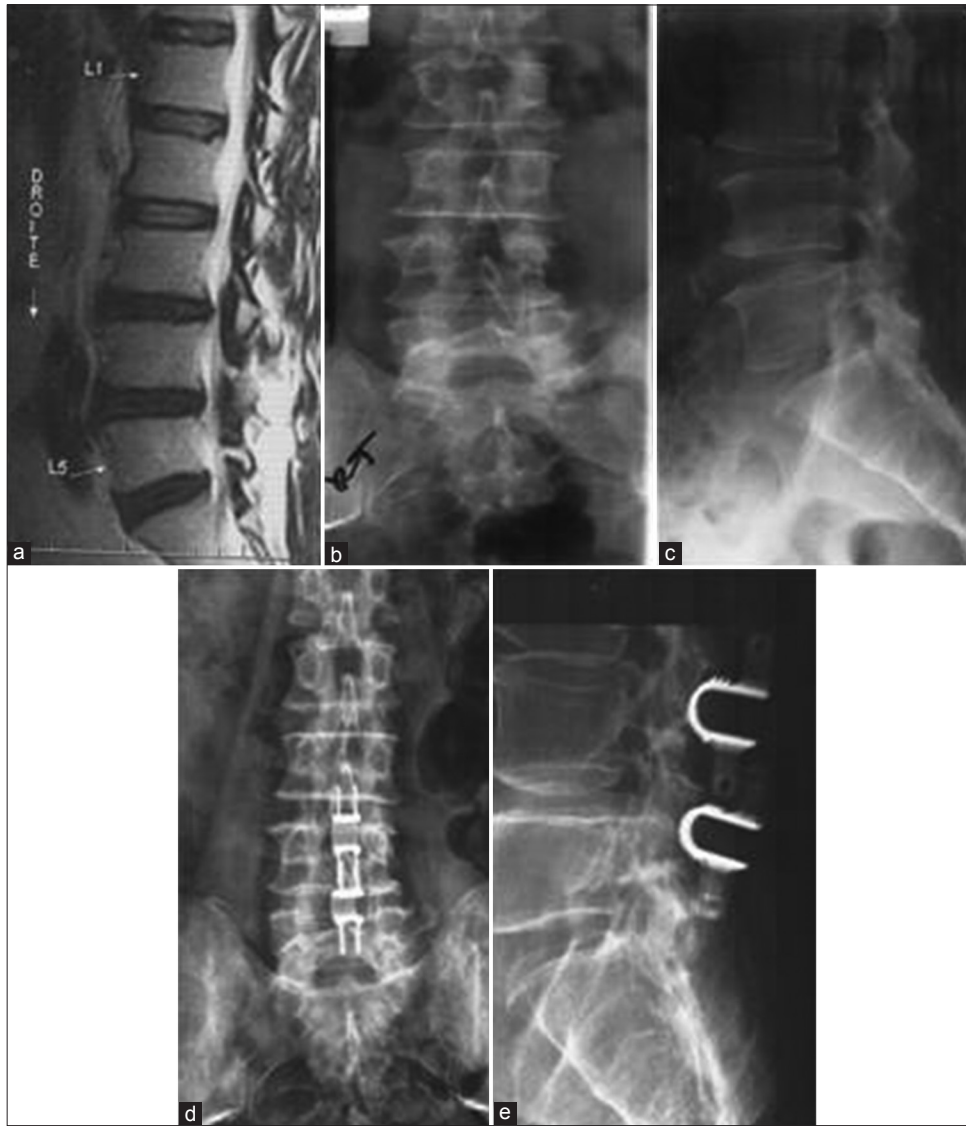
(a) Pre-operative magnetic resonance imaging Sagittal T2 showing L3-L4 suspended vertebrae. (b) Antero posterior lumbar spine X-ray showing L3-L4 suspended vertebrae. (c) Lateral lumbar spine X-ray showing L3-L4 suspended vertebrae. (d) Post-operative Antero posterior lumbar spine X-ray after insertion of L2-L3 and L3-L4 interspinous distracter. (e) Post-operative lateral lumbar spine X-ray after insertion of L2-L3 and L3-L4 ISD
